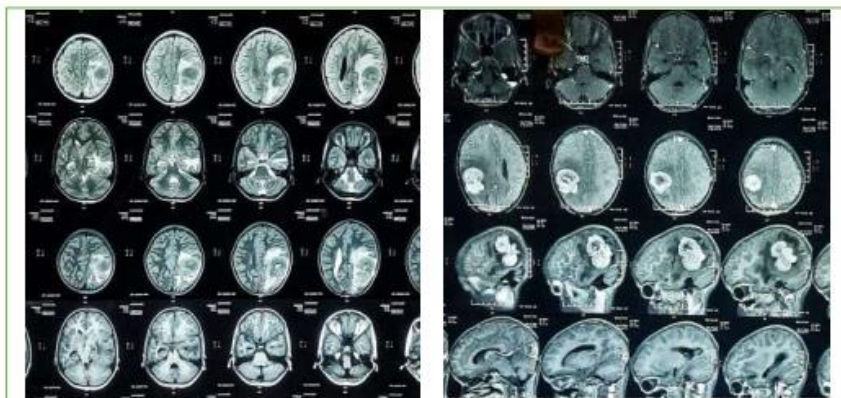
C-MRI (BRAIN) – Lesion shows T1 heterogenous hypointense, T2/Flair heterogenous hyperintense
